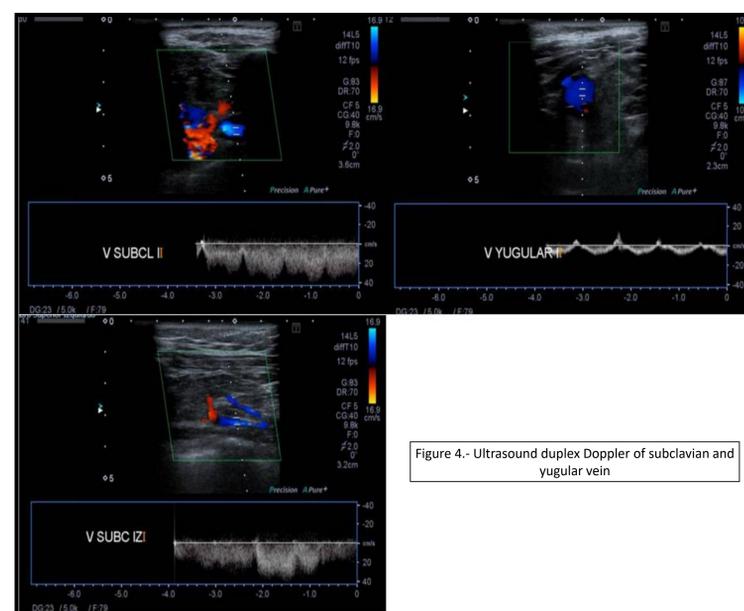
Ultrasound duplex Doppler of subclavian and jugular vein
